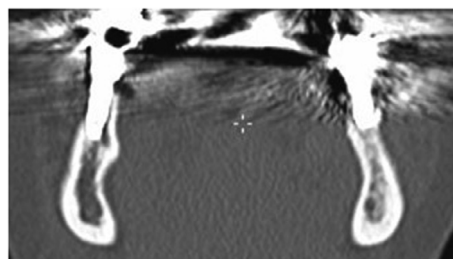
CT-scan image showing a mandibular sclerosis localized around the implant 37 having developed a MRONJ.
